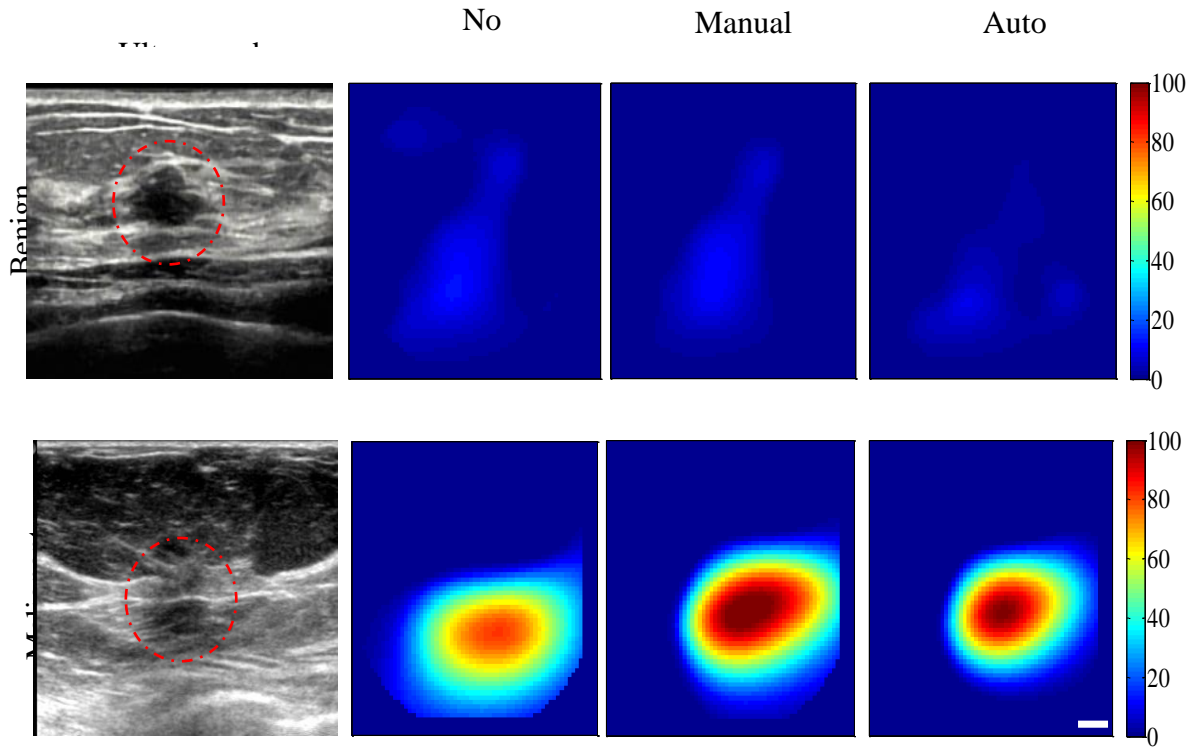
Ultrasound image (1st column) and total hemoglobin map calculated with no data selection (2nd column), with manual data selection (3rd column) and automatic data selection (4th column) of the benign (top row) and the malignant breast lesion (bottom row) reconstructed with automated data selection method. Each slide is 9 cm by 9 cm and vertical bars are hemoglobin concentrations in uM unit.
